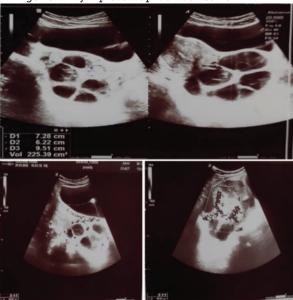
USG And Doppler Findings Of Bilateral Ovarian Masses
